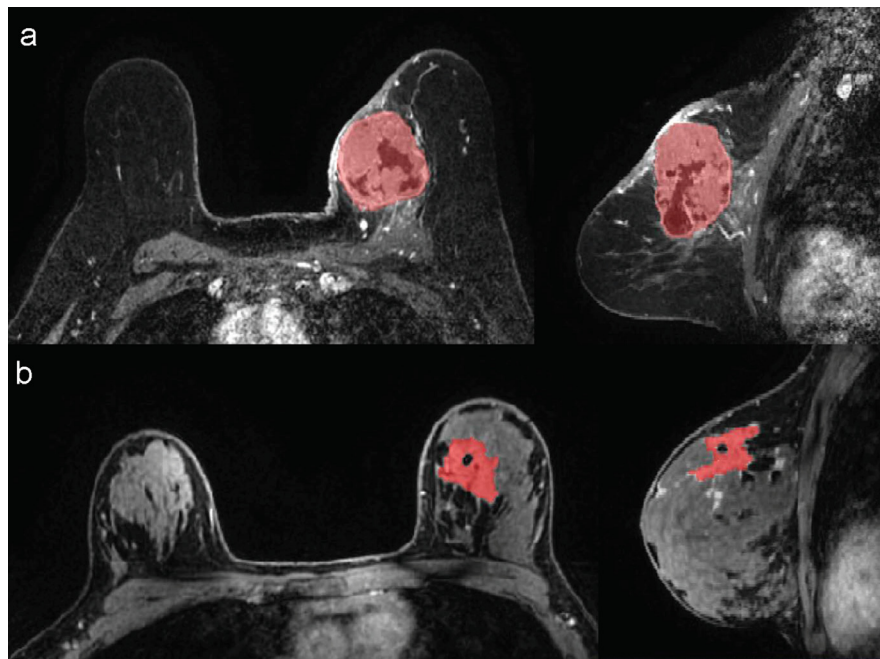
Examples of 3D segmentations of HER2 overexpressing breast carcinomas in the breast MRI's first minute post-contrast sequence. a) Unifocal tumour (whole tumour was segmented). b) Multifocal tumour (only the largest lesion was segmented).
